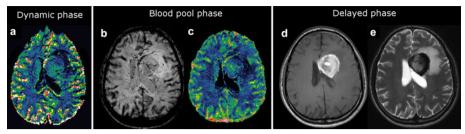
Perfusion and MRI sequences of a patient with CNS lymphoma after ferumoxytol administration. Part a shows dynamic-phase cerebral blood volume with slightly increased uptake in the tumour. Part b shows abnormal vasculature on susceptibility-weighted imaging. Part c shows increased blood flow in the tumour. Parts d and e show T1 hyperintensity and T2 hypointensity, respectively (Reprinted with permission from Toth et al. (2017), copyright Elsevier 2017)
